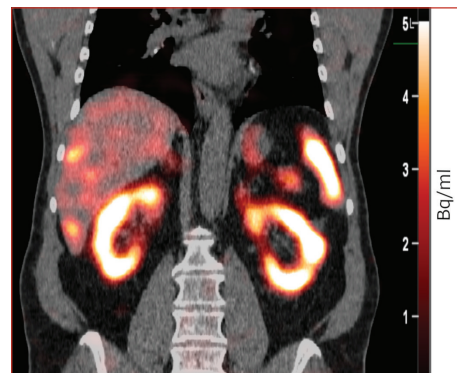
Quantitative fused (i.e., SPECT + CT) image with colorbar showing units of Bq/ml.
